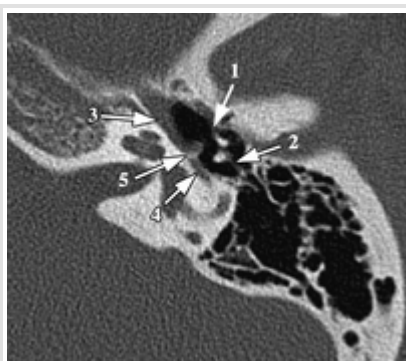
Transverse multi-detector row CT scan of a normal left temporal bone. The anterior malleal ligament (1) and the posterior incudal ligament (2) are shown, as well as the tensor tympani muscle (3), the S2 segment of the facial nerve (4), and the cochleariform process (5).
